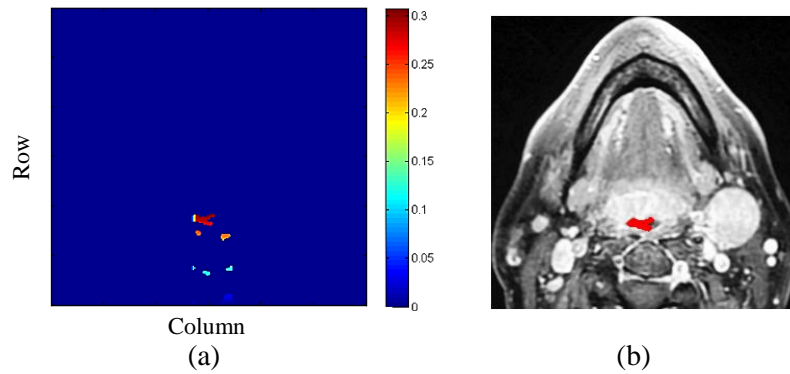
(a) $F_{Intersect}$: Intersection of F_{VL} and B_I (b) detected throat region pixels (in red) as highest membership of $F_{Intersect}$ from a MRI slice.
